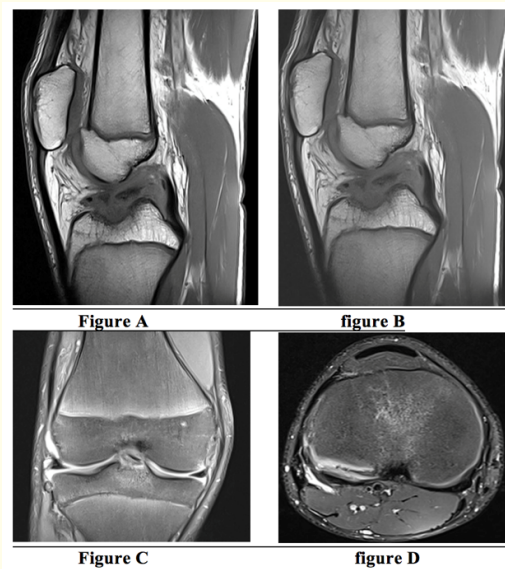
15-year-old child, former trauma to the right knee, currently he presents with pain on the lateral side of the knee in which the MRI of the knee shows a complete rupture of the ACL with verticalized S-shaped aspect of the PCL.
